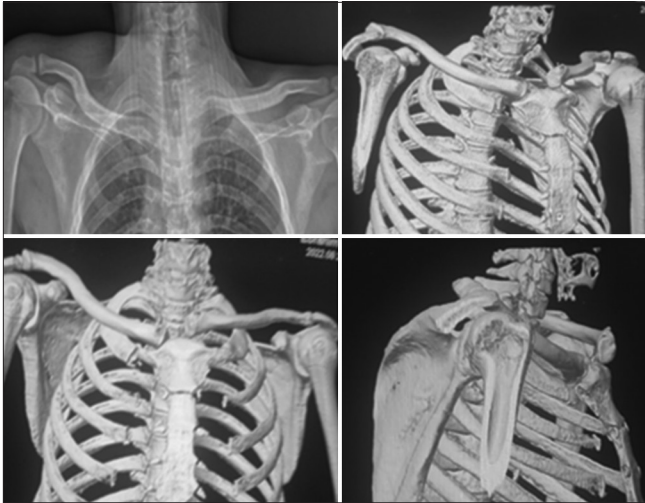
Plain radiography and CT 3D show dislocation of the left sternoclavicular joint.
